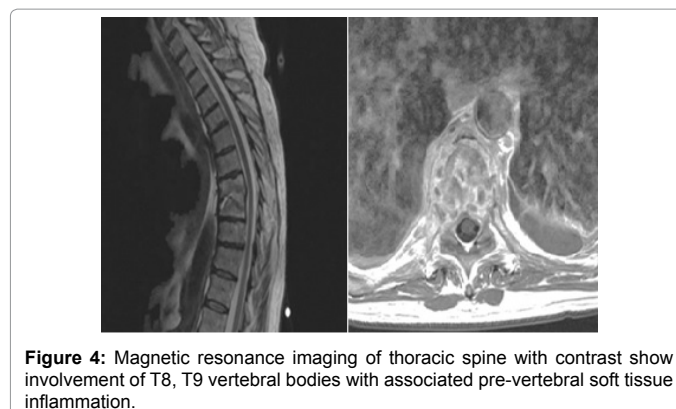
Magnetic resonance imaging of thoracic spine with contrast show involvement of T8, T9 vertebral bodies with associated pre-vertebral soft tissue inflammation.
